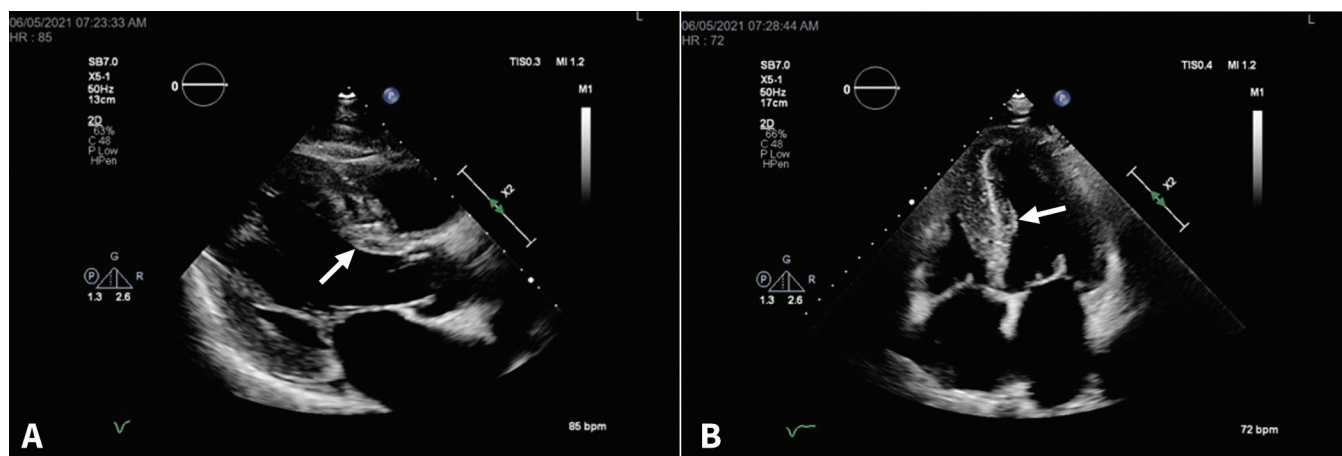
Transthoracic echocardiogram (parasternal long axis [A], apical 4 chamber [B]) showing increased septal thickening (arrows).
